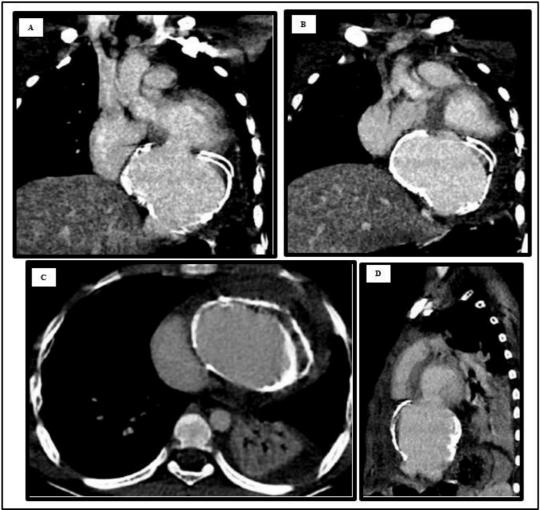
(A - B): CT topogram shows a well - defined, elliptical, diffuse eggshell calcification of size 8.1 x 5.2 cm, involving most of the left cardiac silhouette.
